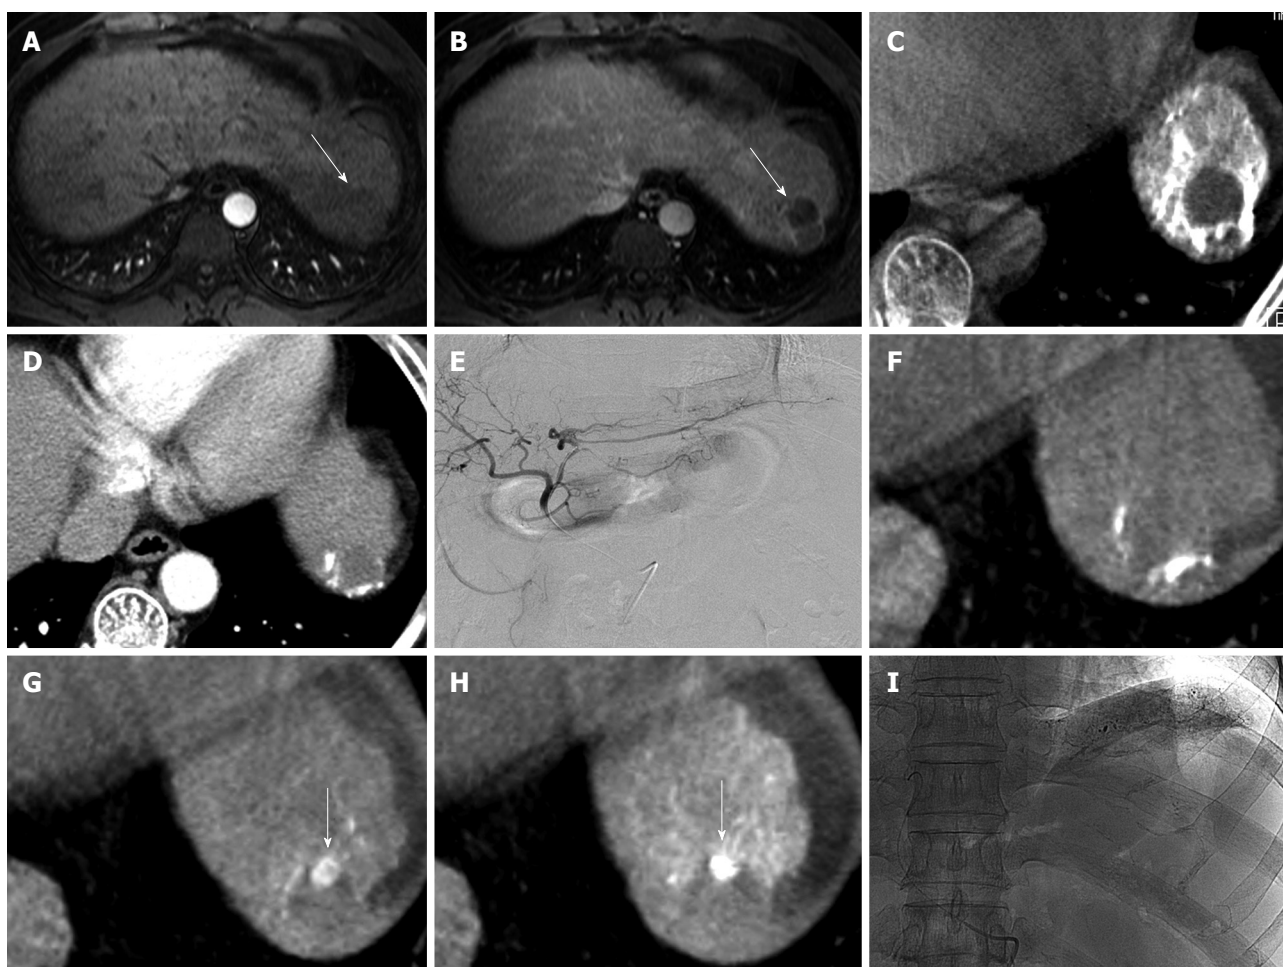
A 52-year-old man with HCC in S2 for 2nd TACE. A, B: Early arterial phase (A) and delayed phase (B) of MRI reveals nodule (arrow) in segment 2 with no enhancement (arrow); C: Cone-beam CT after TACE shows poor grade of iodized oil uptake by the tumor; D: Early arterial phase of MDCT shows washout of iodized oil uptake near nodule, but no enhancing portion within the nodule 3 mo later; E: Left hepatic angiogram during TACE reveals no tumor and feeding artery 1 mo later; F, G: Cone-beam CT with (F) and without (G) hepatic arteriography shows small enhancing nodule (arrow) in the nodule; H, I: Cone-beam CT after infusion of emulsion (H) shows excellent grade iodized oil uptake by the nodule (arrow). This case shows typical "nodule-in-nodule" appearance of HCC, but spot image (I) did not distinguish nodular uptake.
